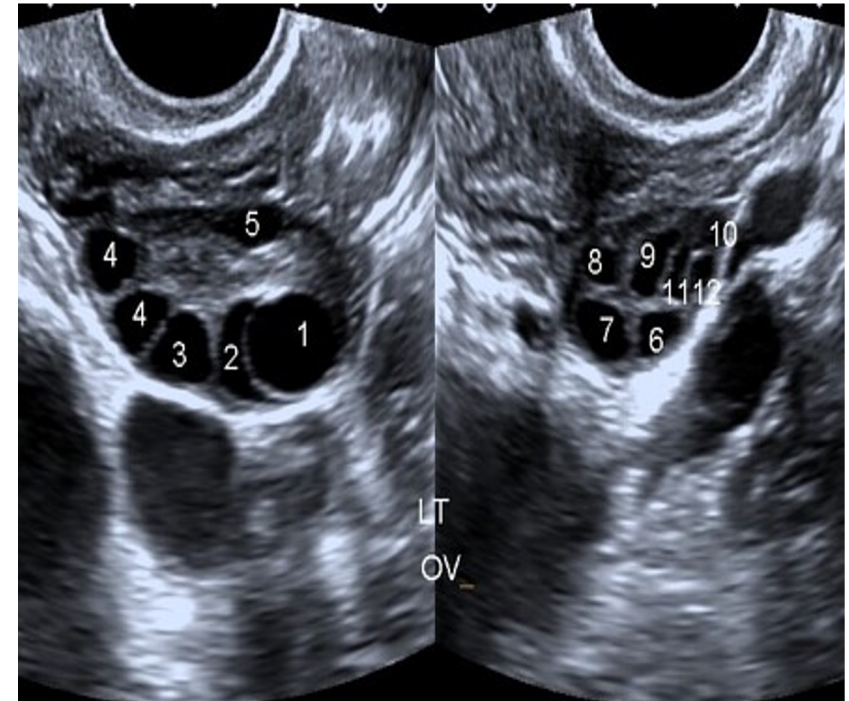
Ultrasound pictures of a polycystic Ovary
